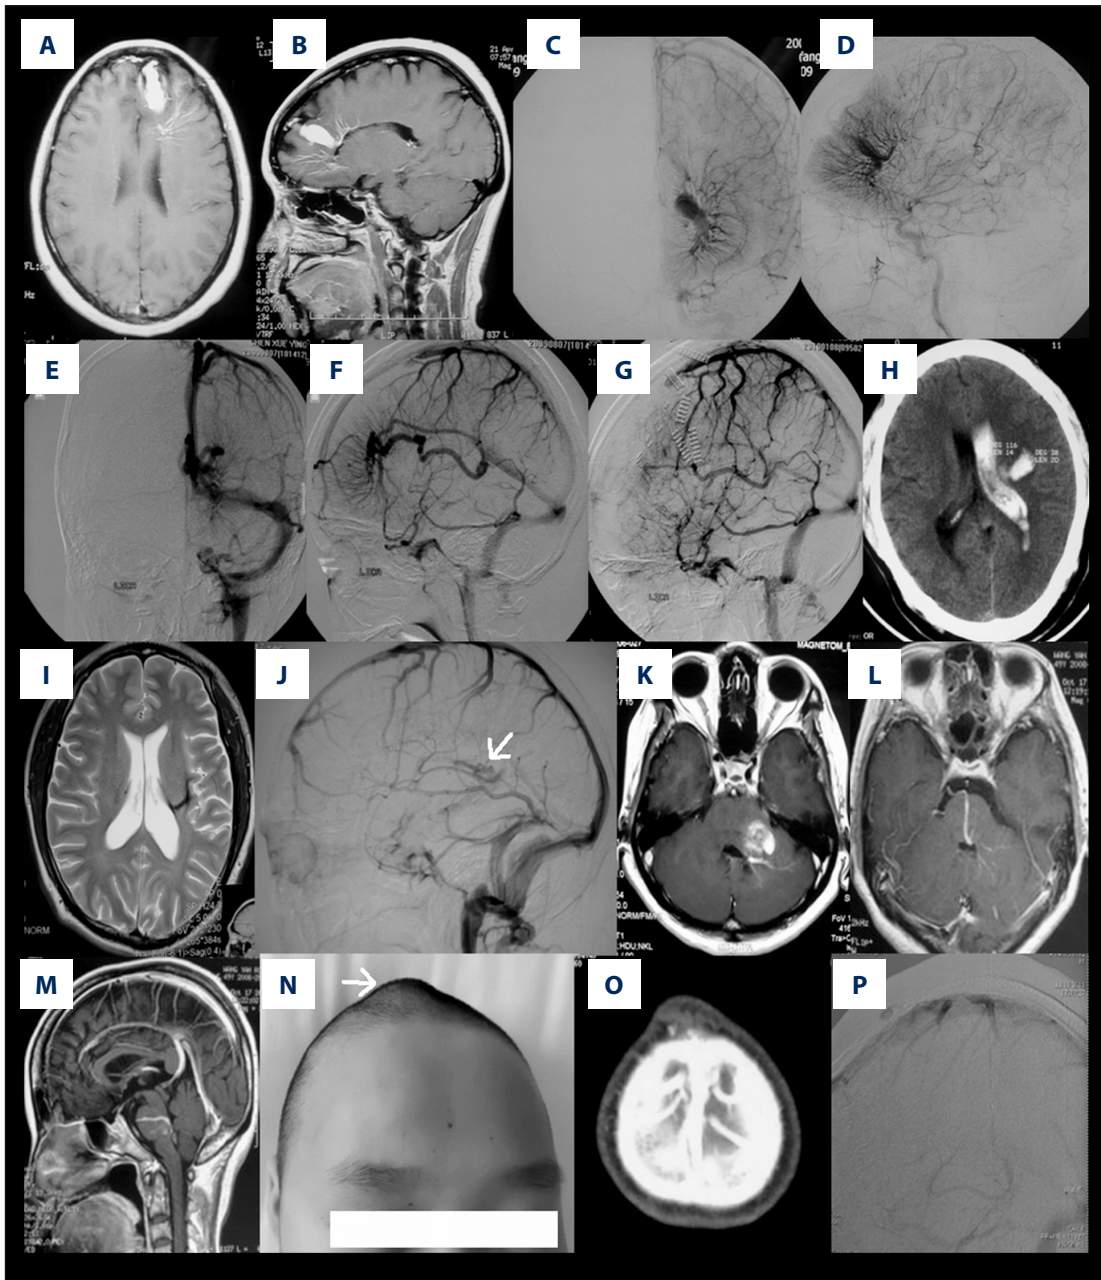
The morphological features of DVAs in different subtypes. (A–D) Demonstrate typical type A DVAs, axial and sagittal MR view (A, B) showing medullary veins arranged in stellate configuration and converged to an enlarged vein draining into a superficial cortical vein; anterior-posterior and lateral view of DSA (C, D) showing a “caput medusae”-like collections of dilated medullary veins converging in superior sagittal sinus during the late venous phase. (E–G) Demonstrate typical type B DVAs, anterior-posterior and lateral view of DSA show umbrella-shaped medullary veins converged and drained into the internal cerebral vein and then into Galen vein (E, F). Postoperatively, abnormal vessels were resected, epilepsy disappeared and deep draining vein was preserved (G). (H–J) Demonstrate type C DVAs. CT scan showing intraventricular hemorrhage (H), MRI showing an enlarged vein drained into a subependymal vein (I). (J) Showing abnormal veins in the lateral view of DSA (white arrow). (K) Demonstrate typical type D DVAs, an enlarged vein drained into a subependymal vein in the fourth ventricle, associated with a cavernous malformation in the brachium pontis. (L, M) Demonstrate a draining vein collecting deep cerebellar blood and coursed as an anterior transpontine vein and drained into the pontomesencephalic vein (Type E). (N–P) Demonstrate typical type F DVAs, non-pulsive soft scalp swelling could be seen in the frontal midline area (N, white arrow). Subcutaneous sinus pericranii was shown in CTA (O). In the lateral view of DSA, abnormal vein was demonstrated (P).
